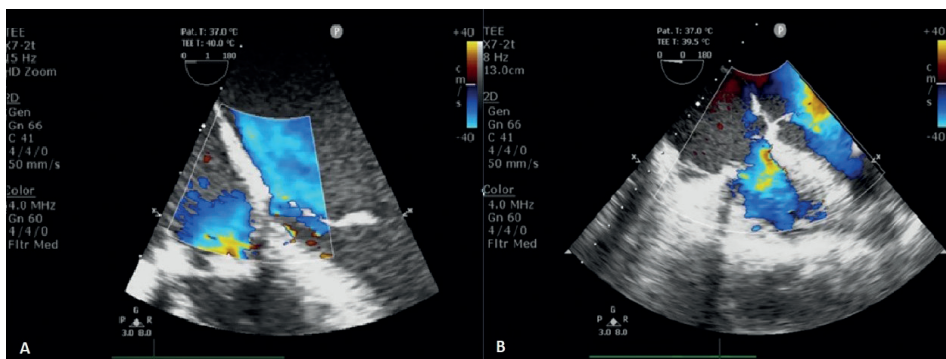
(3A, 3B) Transthoracic echocardiogram (TTE) following vegetation removal, tricuspid valve repair and VSD closure
